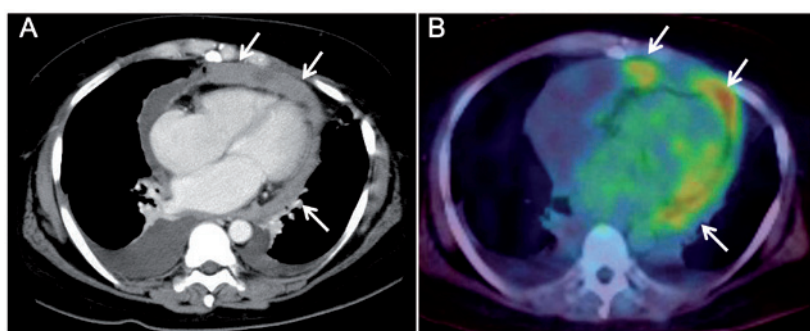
(A) Chest computed tomography revealed an irregular, thickened pericardium with diffuse enhancement (arrows), loculated large amounts of pericardial effusion and bilateral pleural effusions. (B) Fluorodeoxyglucose (FDG) positron emission tomography imaging demonstrated intrapericardial FDG accumulation (arrows) with a standardized uptake value of 6.0.
